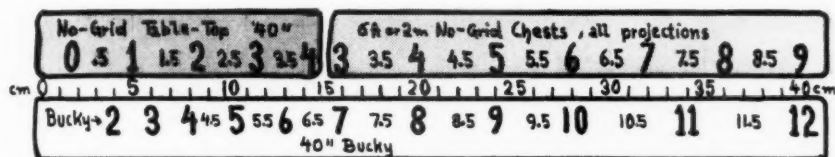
Standard unit caliper scale for the practical system. This scale can be applied to high- as well as low-kilovolt technics and is basic in that the smallest exposure likely to occur in medical radiography is labeled zero. The highest E.V. figure (12) represents then an exposure more than 4,000 times the former.
